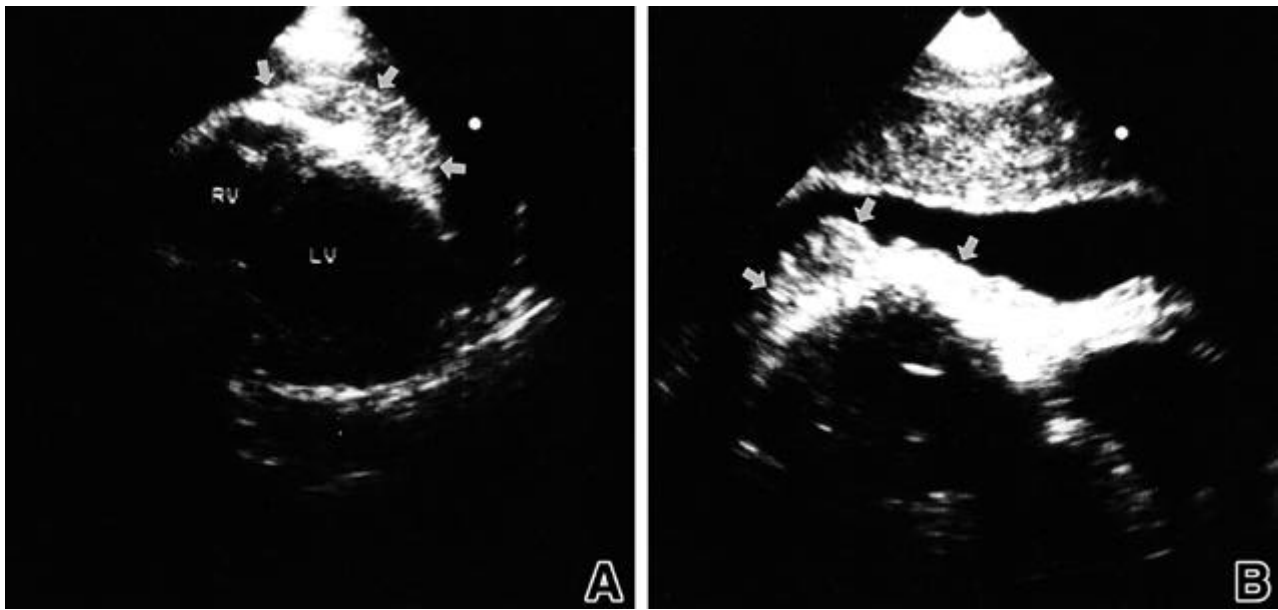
A) apical view, B) subcostal view. Two-dimensional echocardiography showed a large amount of pericardial effusion and hyperechoic mass-like lesion along the pericardium (arrows).
